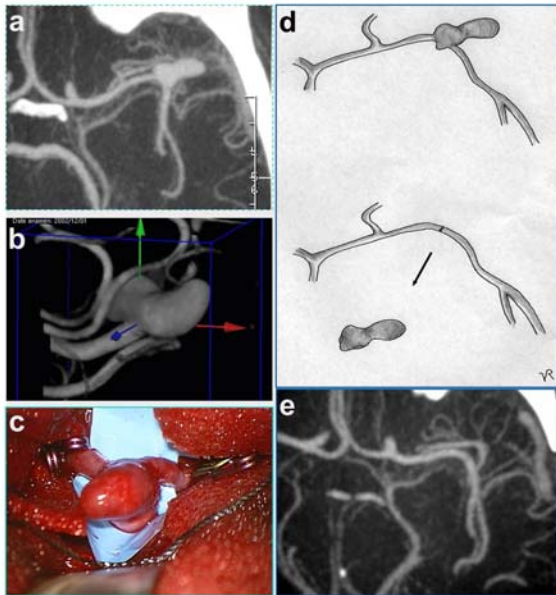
Direct vessels Reconstruction. Pre-operative axial CTA and 3D-DSA showing a complex ruptured aneurysm of the left MCA (WFNS 1) (figures a-b). Intraoperatively, after aneurysm dissection (figure c), direct vessels reconstruction was considered feasible. So the aneurysm was excised and an “end-to-end” anastomosis between the two MCA stumps was performed (figure d). Post-operative CTA showed excellent results with aneurysm disappearance and the patency of the anastomosis (figure e).
